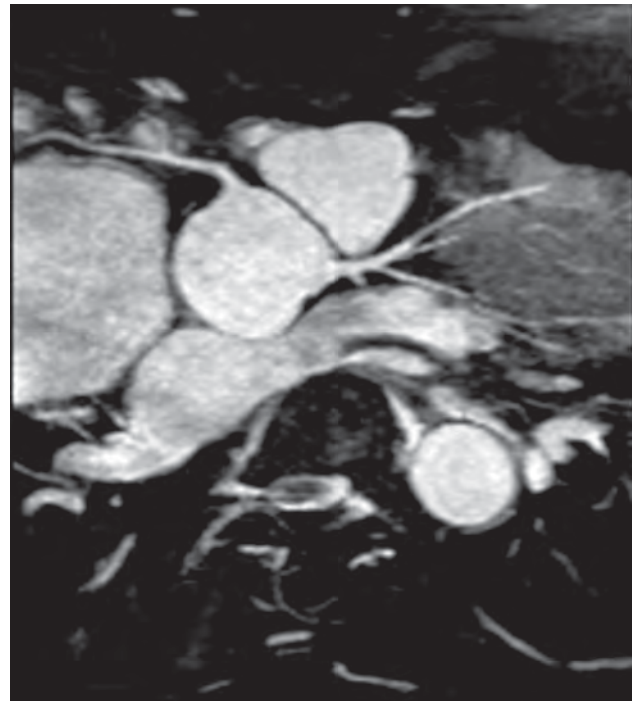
Normal coronary artery origins, as seen on cardiac MRI. The right and left coronary arteries arise from their respective sinuses of Valsalva.
